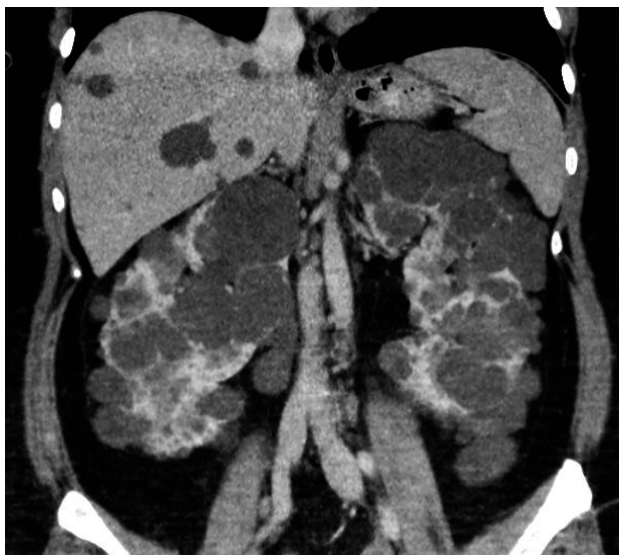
Spiral computed tomography scan.
